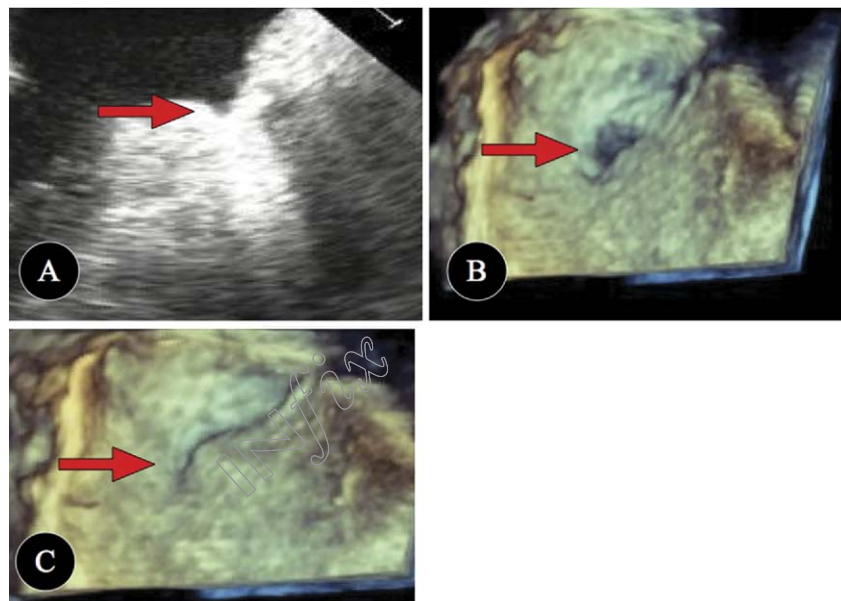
Demonstrates residual stump after first resection of left atrial appendage (LAA) in two-dimensional (panel A) and three-dimensional (3-D) transesophageal echocardiographic (TEE) (panel B). Panel C shows 3-D TEE image confirming complete obliteration of LAA after placing additional sutures.
